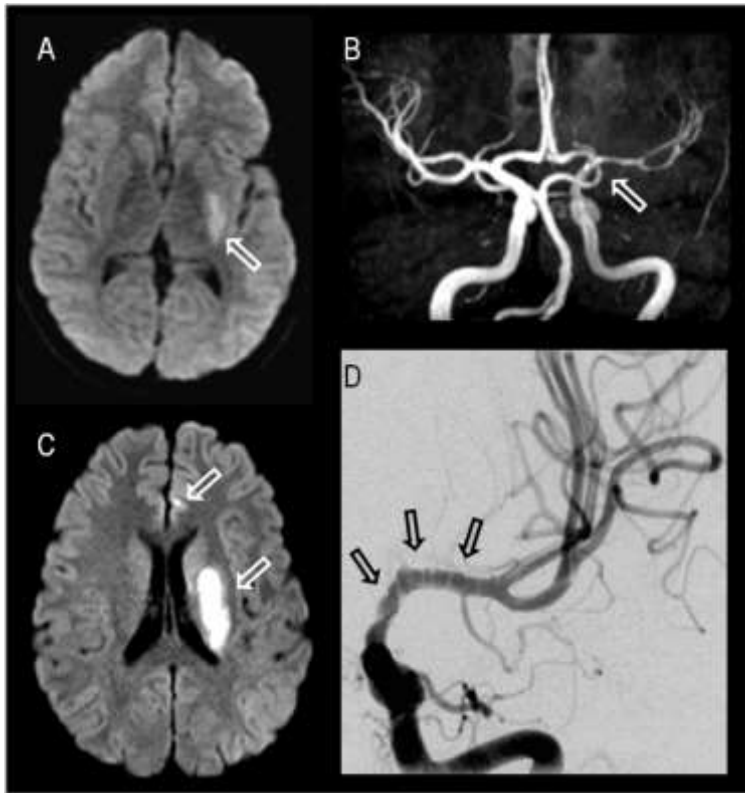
Focal cerebral arteriopathy and AIS in a 15-year-old boy with acute right hemiplegia and hemianesthesia. (A) Diffusion MRI on day 1 shows faint restricted diffusion limited to the posterior putamen and internal capsule. (B) MRA shows reduced ICA and MCA flow with irregular narrowing of left MCA (arrow). (C) Repeat diffusion MRI on day 11 shows new restricted diffusion extending throughout the corona radiata and small cortical areas within the MCA and ACA territories (arrows). (D) Conventional angiography (left ICA injection) demonstrates severe irregularity of the distal ICA and proximal MCA with alternating “bands” of narrowing. The ACA is now occluded.
